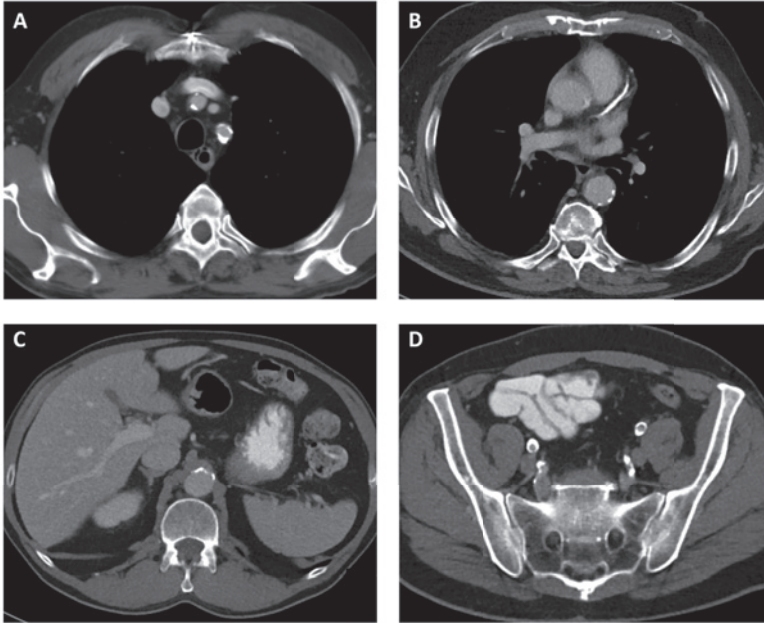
Examples of preoperative CT images of arterial calcification in patients with esophageal cancer. A: Calcification of the brachiocephalic and left subclavian artery, resulting in a score of 2 for calcification of the supra-aortic arteries. B: Calcification of a large segment of the left anterior descending artery, resulting in a score of 2 for calcification of coronary arteries. C: Calcification of the celiac axis with a maximum cross-sectional diameter of >10 mm, resulting in a score of 2 for calcification of the celiac axis. D: Multiple calcified foci of the internal and external iliac arteries, resulting in a score of 2 for calcification of the internal and external iliac arteries.
